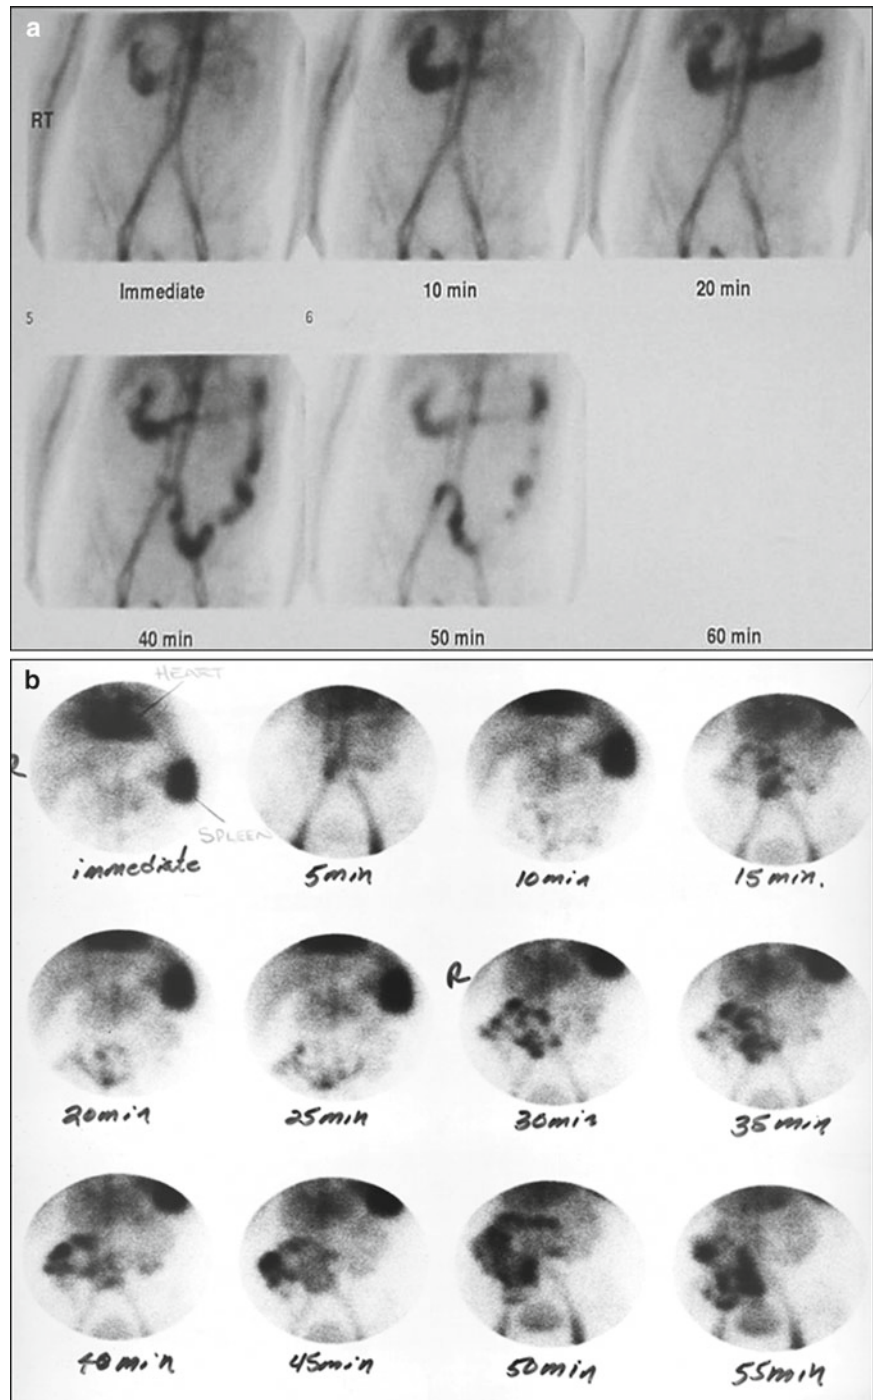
(a) Hepatic flexure of the colon bleeding on scintigraphy showing increased accumulation and movement of the radiotracer in the bowel lumen over time. (b) Small bowel bleeding on scintigraphy. (Courtesy of Dr. Leonard Freeman, Professor of Nuclear Medicine and Radiology, Montefiore Medical Center, Albert Einstein College of Medicine)
